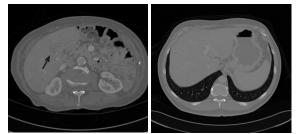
Sample of the original abdominal CT images used during the preliminary evaluation.
